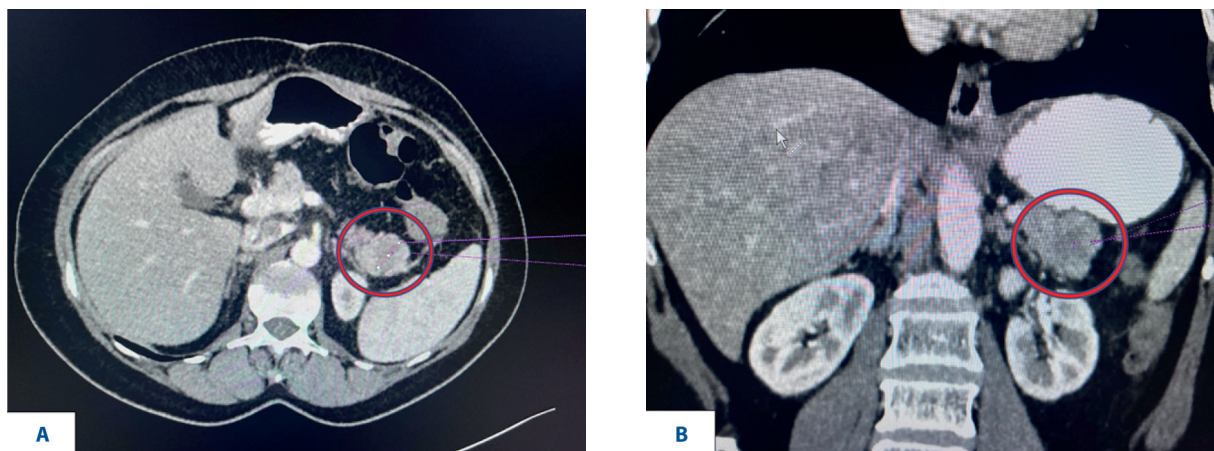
Computed tomography images of the metastatic pancreatic tumor before excision. A – image of a 5 cm tumor in the tail of the pancreas – transverse view; B – image of a 5 cm tumor in the tail of the pancreas – coronal view
